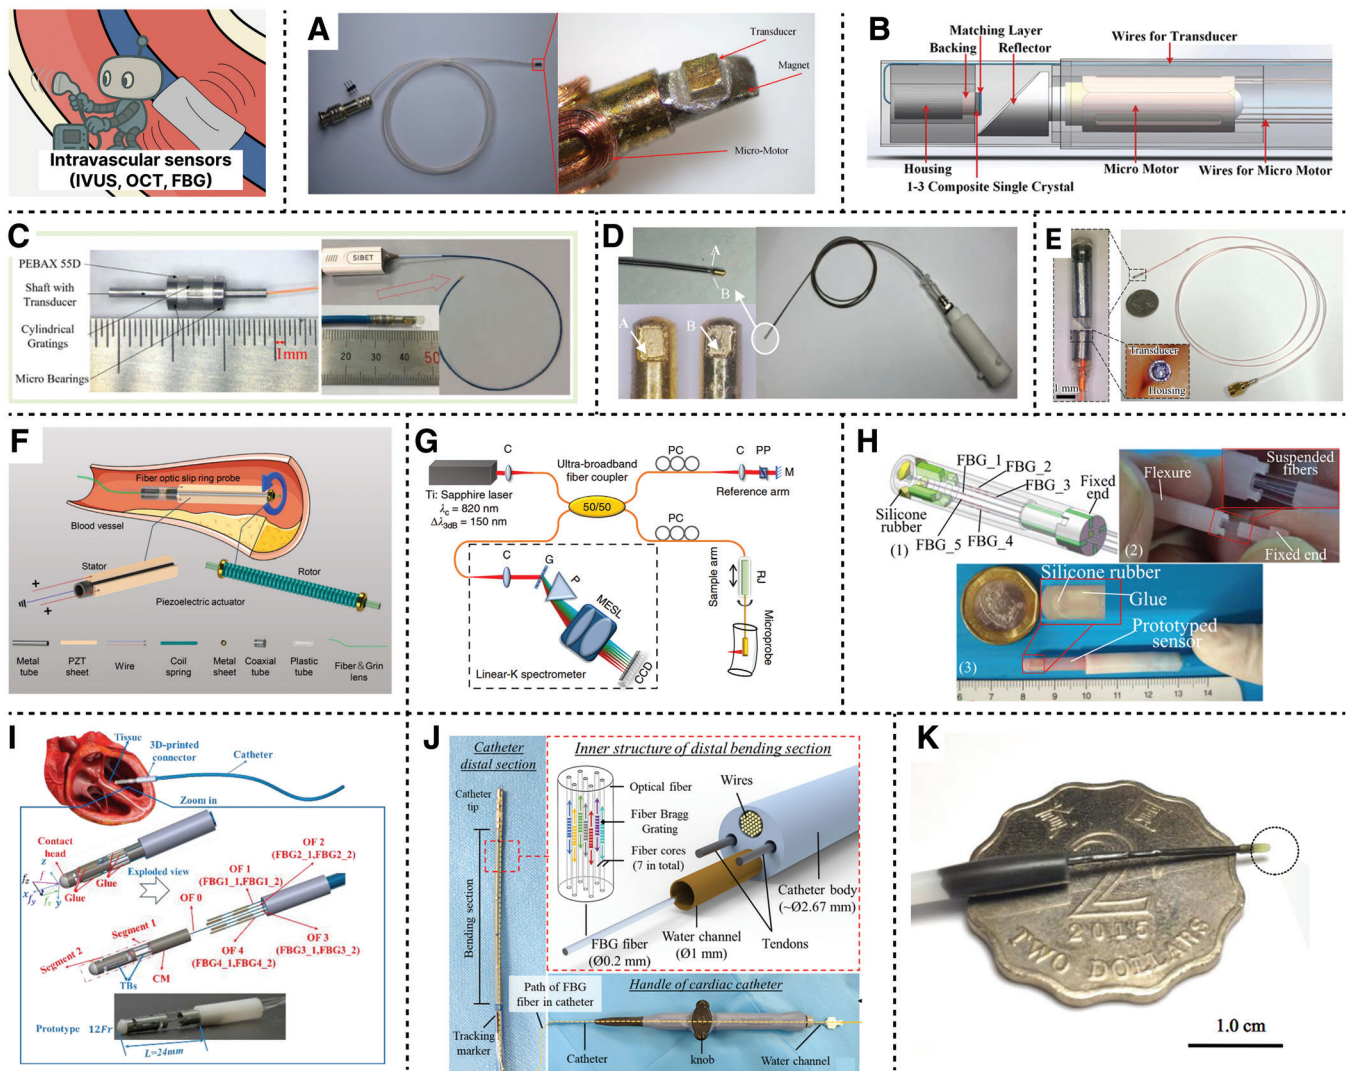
Intravascular sensors. (A) Micromotor-driven side-looking ultrasound catheter. Reproduced with permission from Hou et al.^[66] Copyright 2022, IEEE. (B) Electromagnetic micromotor for stable IVUS rotation. Reproduced with permission from Peng et al.^[67] Copyright 2019, IEEE. (C) Rotary ultrasonic encoder for NURD correction. Reproduced with permission from Han et al.^[68] Copyright 2021, IEEE. (D) A dual-element catheter enabling redundant imaging. Reproduced with permission from Liu et al.^[69] Copyright 2023, IEEE. (E) Magnetically steered IVUS robot with scanning. Reproduced with permission from Yang et al.^[9] Copyright 2025, IEEE. (F) Piezoelectric OCT scanner with FOSR. Reproduced with permission from Wang et al.^[60] Copyright 2023, IEEE. (G) OCT microneedle with laser ablation function. Reproduced with permission from Yuan et al.^[61] Copyright 2020, The American Association for the Advancement of Science. (H) Flexure FBG force sensing catheter. Reproduced with permission from Li et al.^[62] Copyright 2020, IEEE. (I) Miniature FBG sensor with compliant structure. Reproduced with permission from Wang et al.^[63] Copyright 2025, IEEE. (J) MRI-compatible FBG catheter for shape feedback. Reproduced with permission from Dong et al.^[64] Copyright 2022, IEEE. (K) Magnetically actuated FBG-enabled continuum robot. Reproduced with permission from Zhang et al.^[65] Copyright 2024, Springer Nature.
